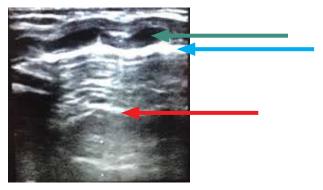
Lung ultrasound: Green arrow: ribs; Blue: pleura; Red: A-lines
